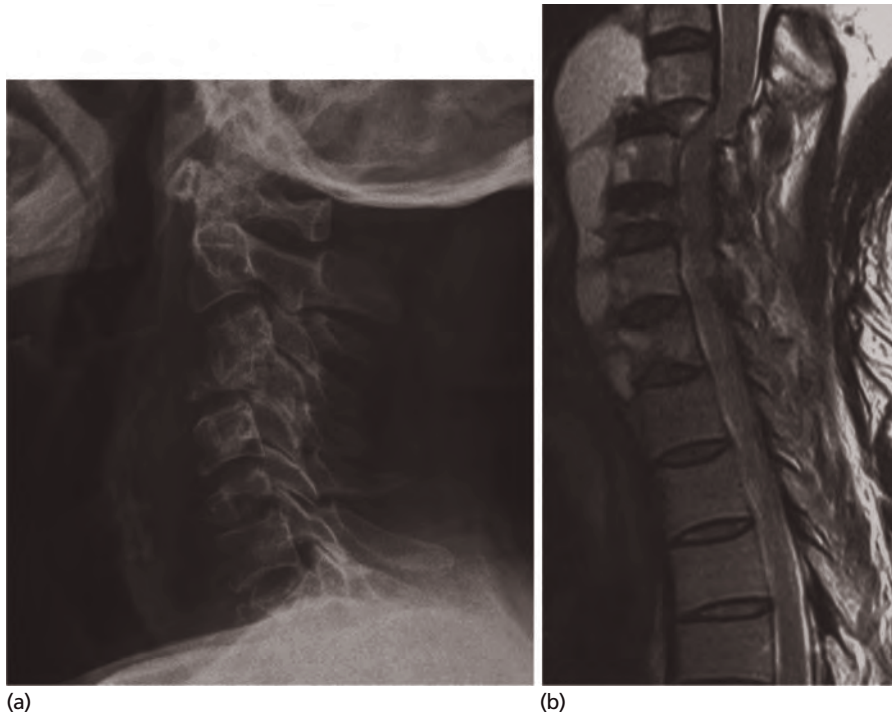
Spinal TB. (a) Pathological collapse C3/4 disc space and C6 vertebra with retropharyngeal swelling (lateral X-ray). (b) Pre-vertebral swelling, kyphosis and cord compression (MRI T2W).
